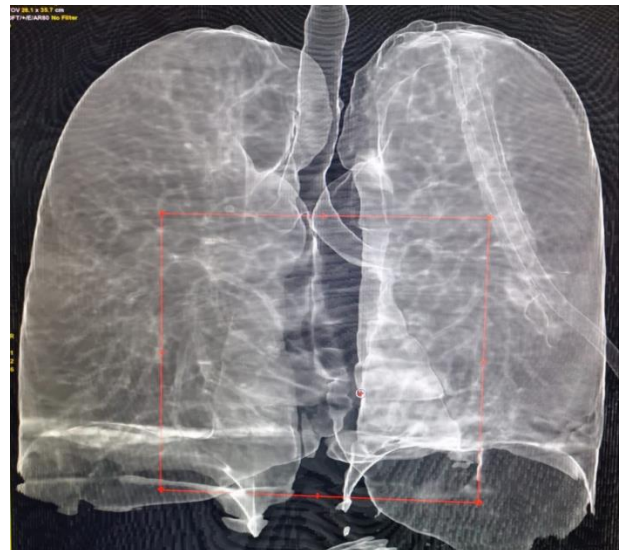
3D reformatting CT image showing Lt apical irregularities denoting multiple Lt apical bullae. Lt lung volume is decreased due to Lt pneumothorax. ICT is seen insitu. A small rt apical bulla is also suggested.
